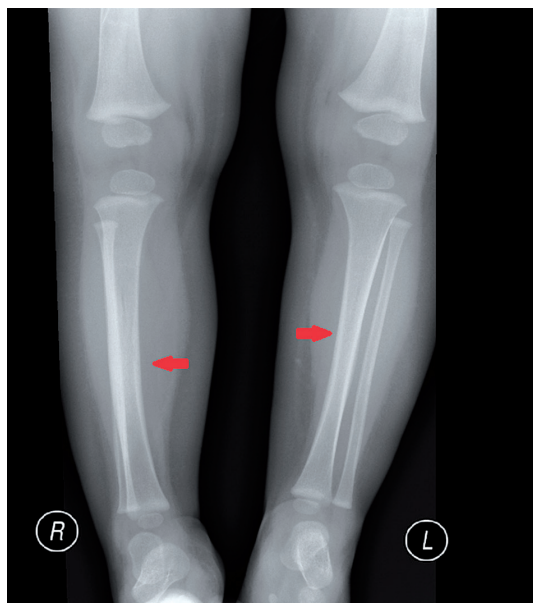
Anteroposterior view of bilateral lower limbs. In the X-ray, intensive periosteal layering along the tibia
